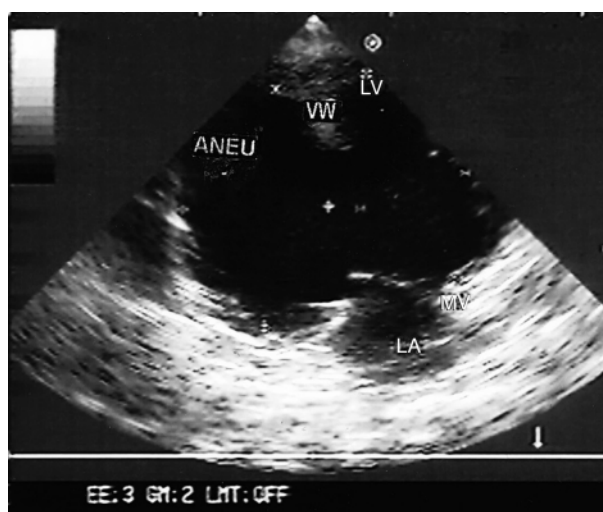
Preoperative echocardiographic view of the pseudoaneurysm. ANEU = pseudoaneurysm, LA = left atrium, LV = left ventricle, MV = mitral value, VW = ventricular wall.
